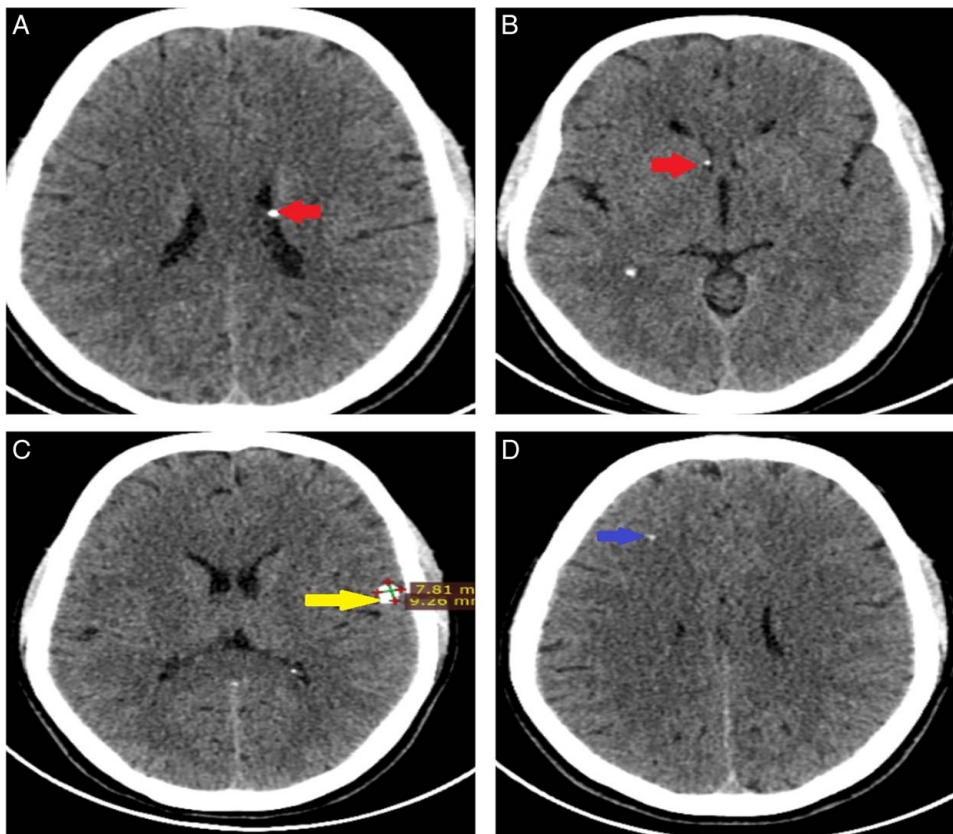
Noncontrast computed tomography images of the head in the axial plane (A–D) shows calcified subependymal nodules in the left lateral ventricle (A) and the frontal horn of right lateral ventricle (B). Approximately 9.2 × 7.8 mm-sized calcified cortical tuber is also noted in the left frontal lobe (yellow arrow in C), and a tiny calcified subcortical tuber is noted in the right frontal lobe (blue arrow in D).
